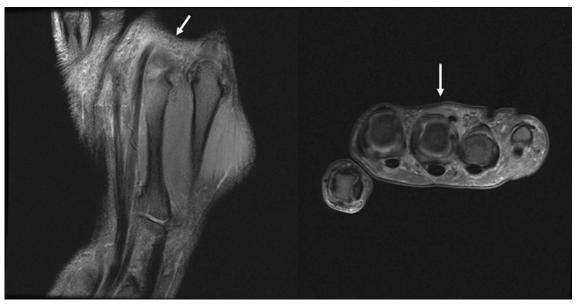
(A) Coronal and (B) axial MRI images demonstrate ulnar subluxation of the extensor tendon following closed blunt trauma to the middle finger MPJ.
